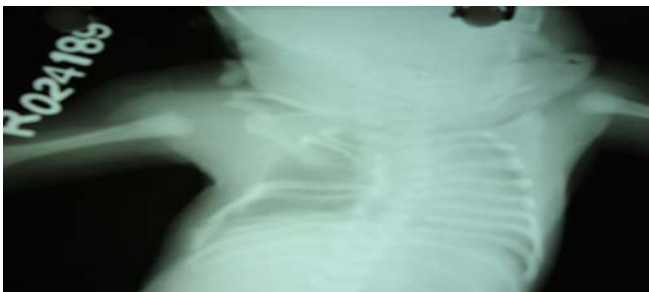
Chest radiograph showing absent 3rd and 7th rib along with fused 4th, 5th and 6th ribs and bifid 8th rib on the right side.
